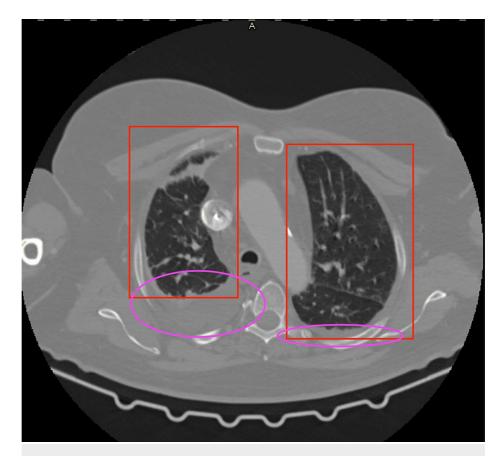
CT scan of the lungs. Upper pulmonary lobes
